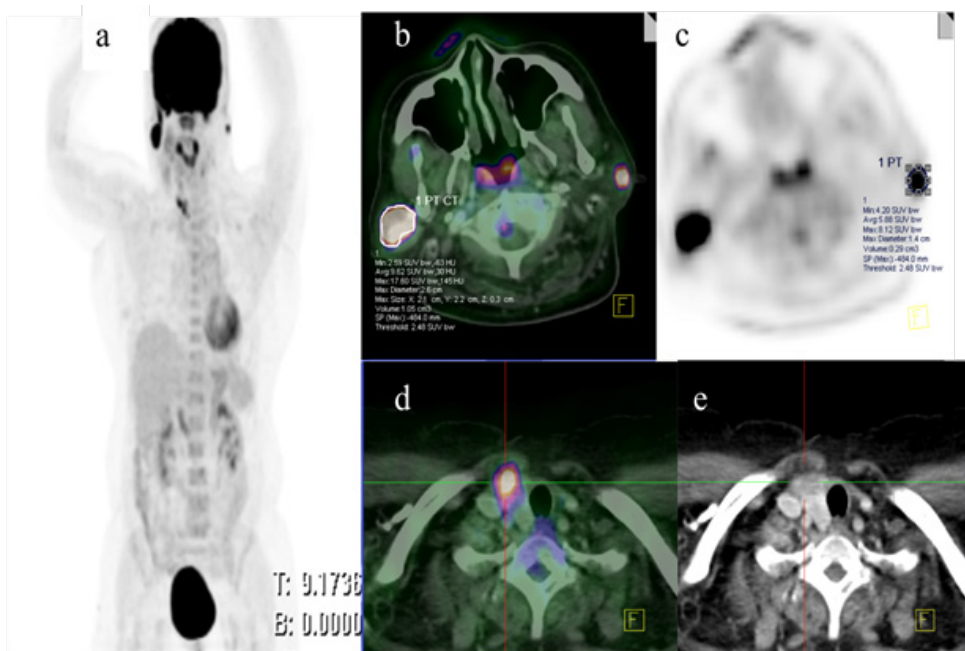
MIP (image a) demonstrate abnormal foci of high FDG uptake in the region of the neck and right upper chest. Integrated fused PET and CT images in the axial plane at the level of the post nasal space (image b) demonstrate increased FDG uptake in both parotids with SUV_{max} 17.6 and 8.1 (image c) in the right and left, respectively. In addition to this finding, there is a foci of high FDG uptake seen in the remnant of the right thyroid lobe (image d), which was reported as normal on initial CT. The corresponding contrasted CT (image e) demonstrates a poorly enhanced low attenuation lesion within the right lobe.
